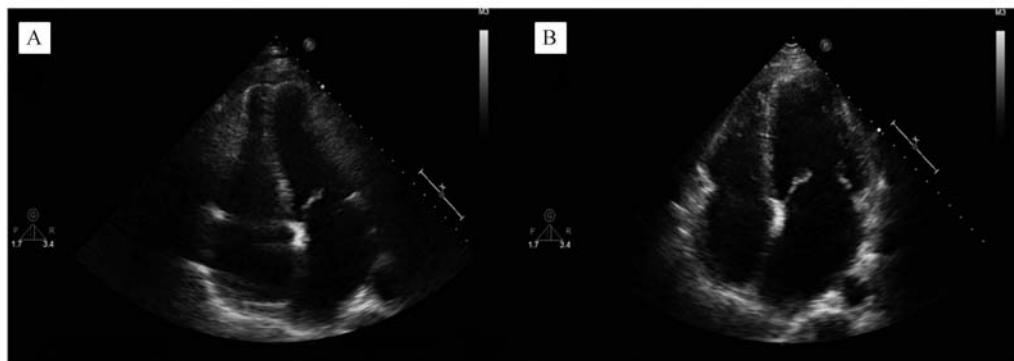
(A) Echocardiography showed biatrial enlargement. The ventricles were deformed; the intermediate part of left and right ventricles was narrower than the cardiac apex. (B) The shape of the ventricles was almost normal after pericardectomy.
